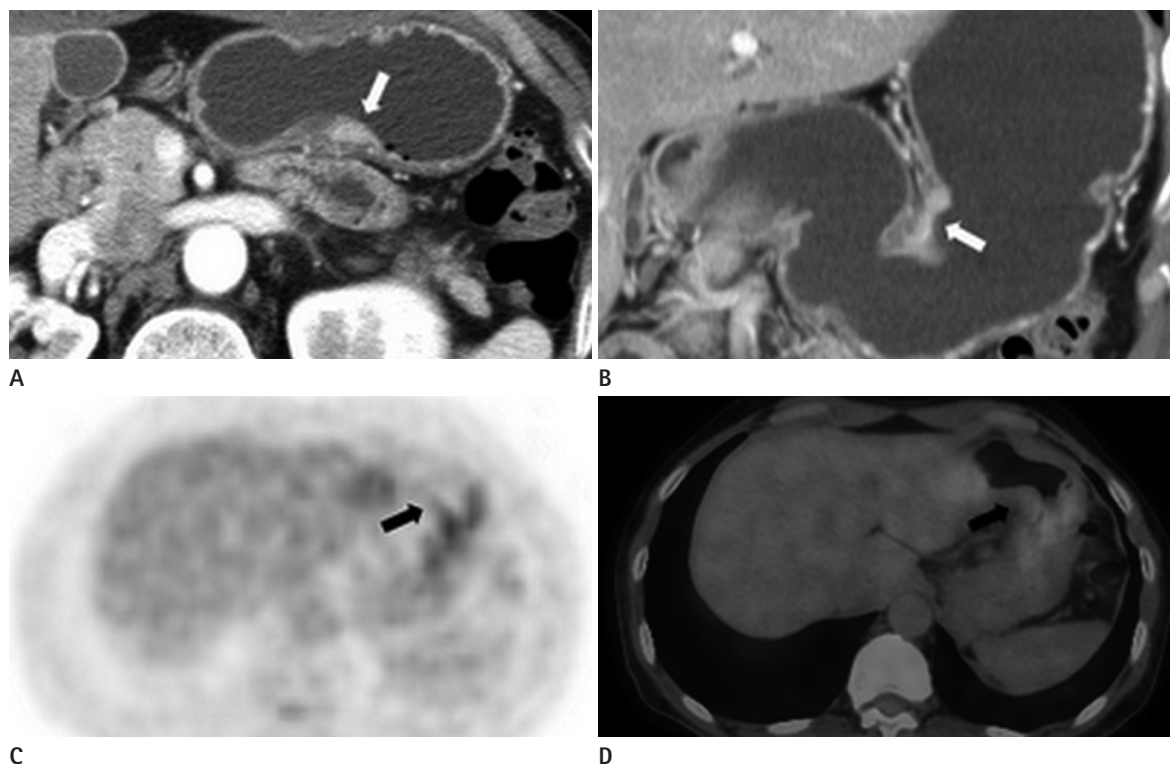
A 55-year-old male with a moderately-differentiated adenocarcinoma of the posterior wall of stomach body (T3). A, B. Axial and coronal CT scan show focal wall thickening and enhancement in the lower body of the stomach, near the angle area (white arrow). C, D. Positron emission tomography (PET) and PET/CT fusion image obtained at the same level show no discernible fluorodeoxyglucose uptake in the stomach (black arrow).
